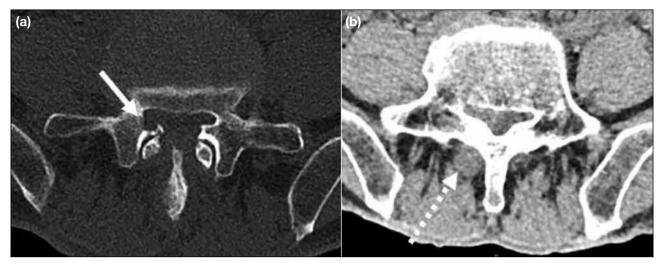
Axial computed tomography showing (a) focal bone erosion at the superior articular process of L5 (arrow) and (b) a small nodular soft tissue lesion posterior to the right L4/5 facet next to the right L5 lamina (dashed arrow).
